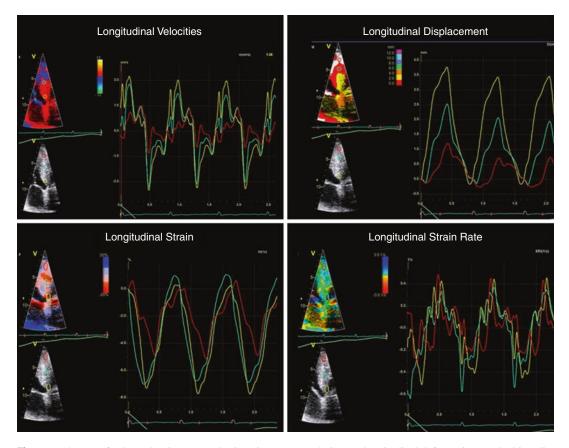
The use of color color tissue Doppler imaging (TDI) to derive LV longitudinal deformations (velocities, displacement, strain, and strain rate) in apical 4-chamber view
